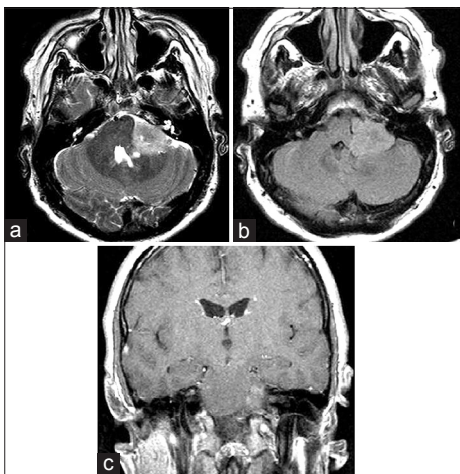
Tanycytic ependymoma. (a) T2-axial MRI showing a hyperintense lesion in the left CPA with extension into the internal auditory canal. The same lesion in axial (b) and coronal (c) views on T1-weighted MRIs. Postgadolinium enhancement showing a homogeneously enhancing lesion extending from the ICA into the left CPA. There are clear mass effect shown on the brainstem and absence of hydrocephalus
